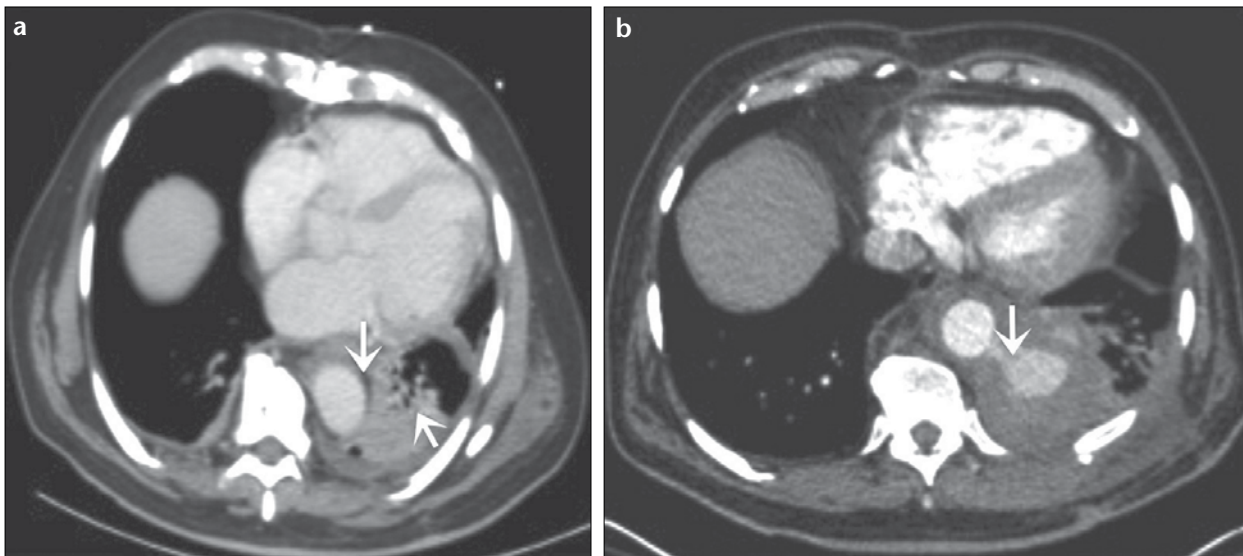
a, b. Axial CT scan demonstrates the air and fluid around the Dacron graft (a, arrows), suggestive for infection. Contrast leak (b, arrow) from proximal anastomosis into left pleural cavity is seen on CT.
